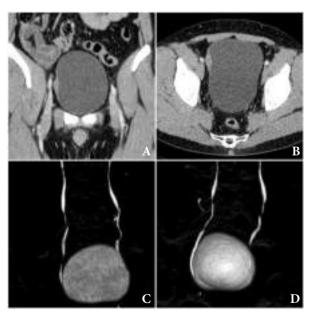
Minor pelvis CT: A - coronal section, venous phase; B - axial section, venous phase; C - 3D reconstruction, front of the urinary bladder; D - 3D reconstruction, back of the urinary bladder
